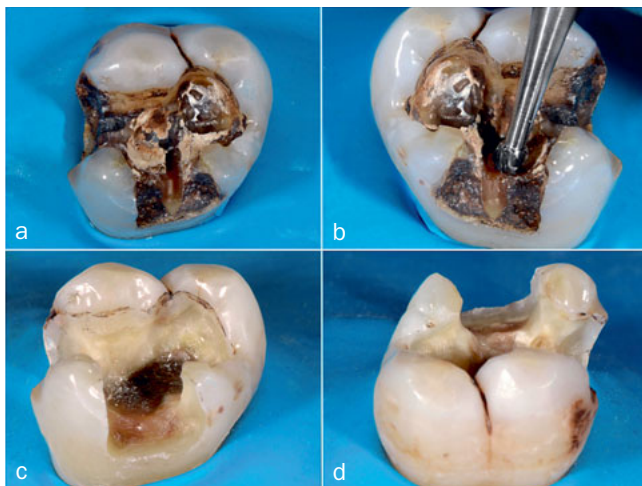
a. The unacceptable amalgam restoration was removed in a minimally invasive way with a multiblade tungsten carbide bur. An ultrasonic device with water cooling can be used to remove the last pieces of amalgam at a low biological cost. b. Caries-infected dentin was removed with a round tungsten carbide bur (Komet H1SEM, Brasseler; Lemgo, Germany) dry and at low speed (7000 rpm). A centripetal approach was followed. This included starting at the periphery towards the critical points. In this way, possible pulp exposure would have been programmed. It is very important that all caries-infected dentin be removed in order to realize a good-quality hybrid layer that will remain stable in the long term. c. After removal of the restoration and all infected tissues, a more detailed biomechanical analysis takes place. The thickness and quality of the cusps, the thickness of marginal ridge and the presence of crack lines was controlled. At the buccal side, the cusps were undermined. Cusp reduction was needed. d. At the palatal cusps, enamel was supported by dentin. Because of the heavy occlusal loading (wear facets) and the crack line at the distal side, the palatal cusps were also reduced.
